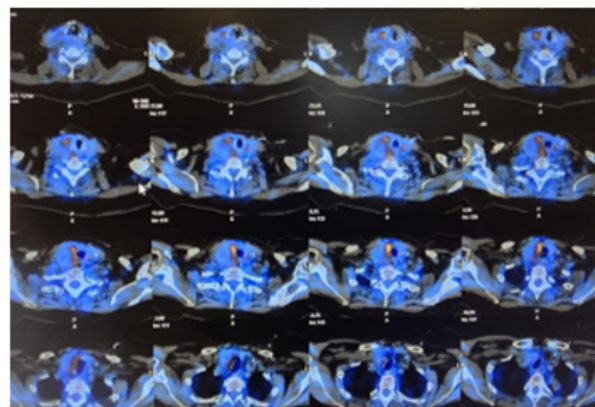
Spect CT scintigraphy without evidence of hyperfunctioning parathyroid glands.
